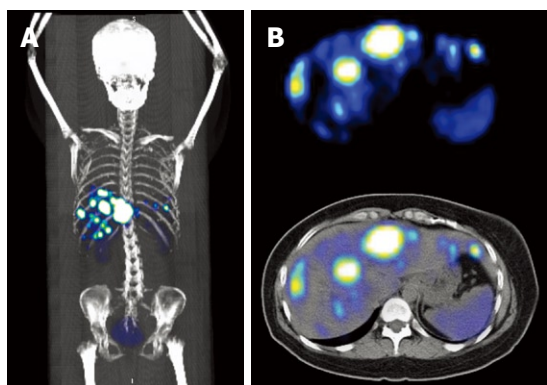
Metastatic pancreatic neuroendocrine carcinoma with multiple liver lesions. A: Coronal 3D reconstruction demonstrates multiple tracer avid lesions sited predominantly in the right hypochondrium; B: Axial PET and PET/CT of the liver shows multiple somatostatin receptor rich lesions in the liver.
